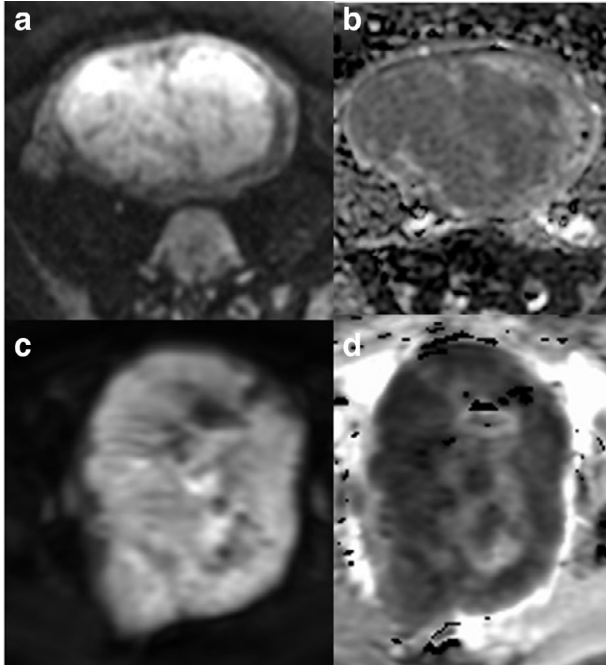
Comparison of DWI imaging in benign (a, b) and malignant (c, d) lesions: axial DWI (a) and ADC (b) of a highly cellular leiomyoma and axial DWI (c) and ADC (d) of a leiomyosarcoma. The DWI outline is helpful in demonstrating the irregular outline in the malignant lesion (c, d). ADC, apparent diffusion coefficient; DWI, diffusion-weighted imaging.
